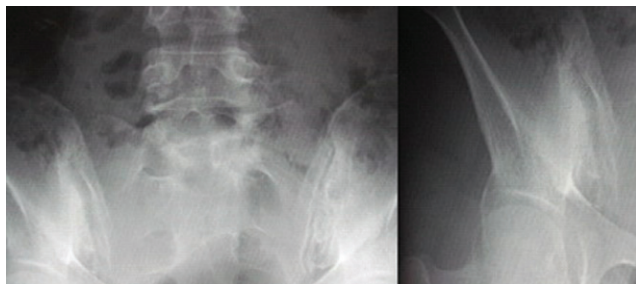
Radiograph of the sacroiliac joint shows sclerosis and narrowing of iliac wing of the right sacroiliac joint.
